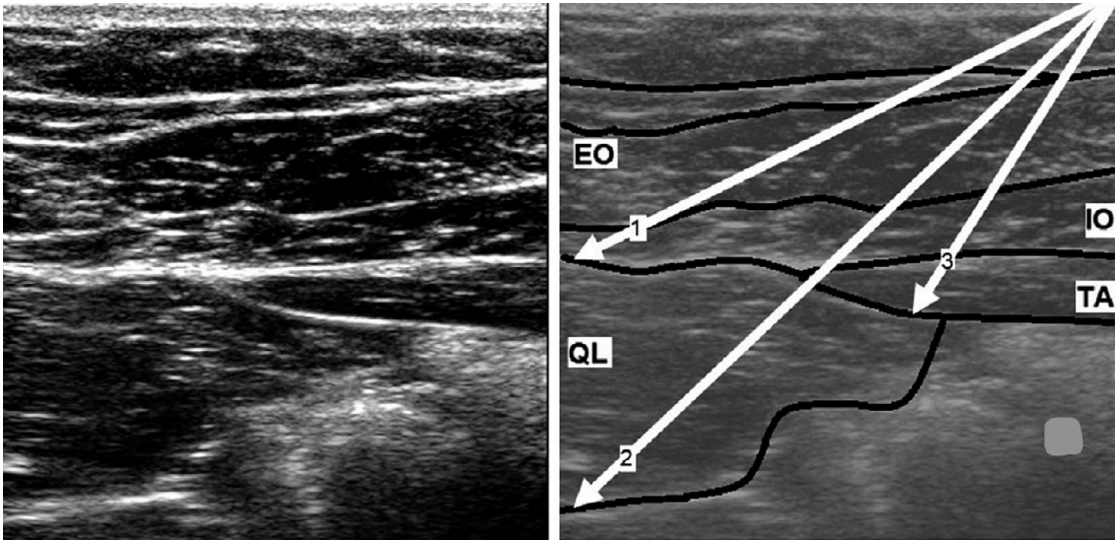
Ultrasound appearance of the quadratus lumborum (QL), external oblique (EO), internal oblique (IO) and transversus abdominis (TA).
